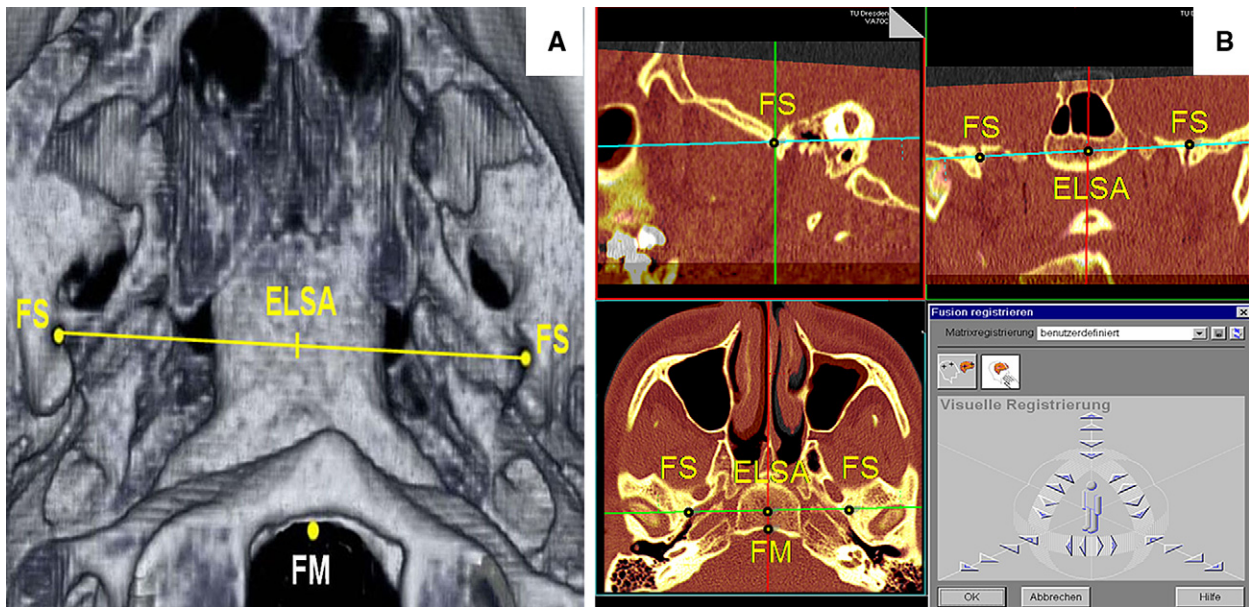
A, Superimposition points: foramina spinosae (FS) and ELSA, the anterior margin of the foramen magnum (FM); B, CT-Osteo-3D-Fusion of T1 and T2 CT scans by using the reference points with the help of the sagittal, coronal, and transverse reference levels.
